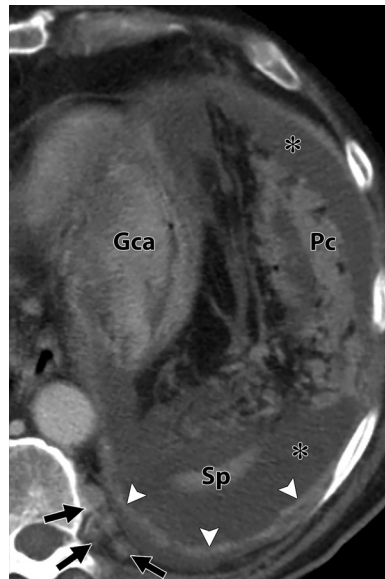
Lymphatic drainage of the posterior costal pleura. Axial CT image shows posterior paraspinous extrapleural lymph node metastases (arrows), pleural effusion, diaphragmatic pleural thickening (arrowheads), and costal pleural thickening. Peritoneal carcinomatosis (*Pc*), lesser curvature gastric carcinoma (*Gca*), and ascites (*) also are seen. *Sp* = spleen.
